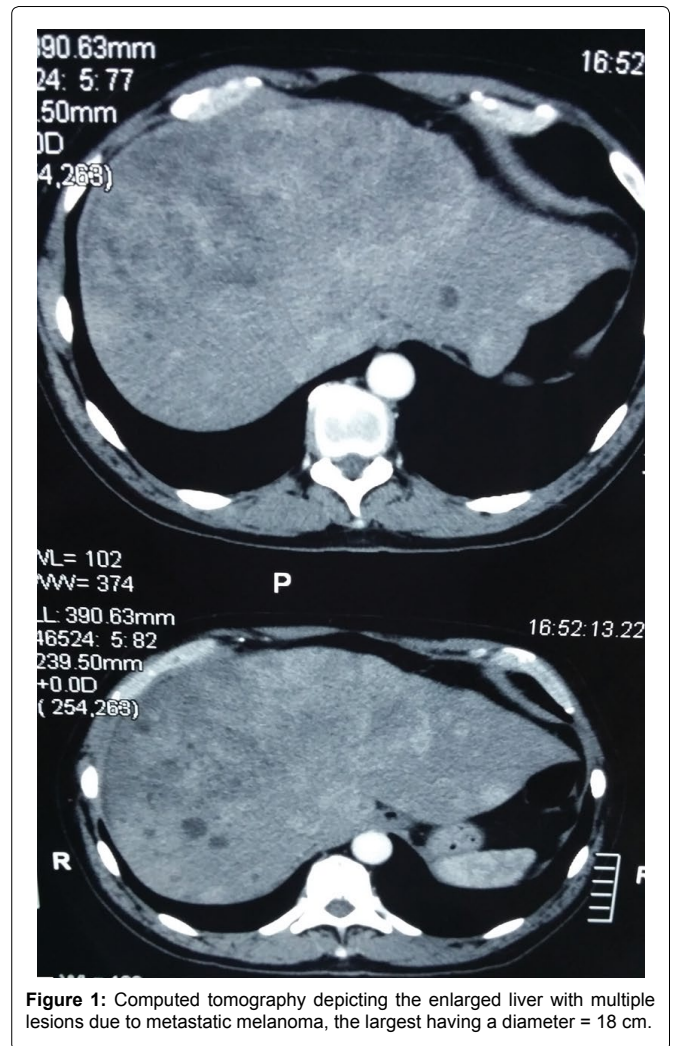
Computed tomography depicting the enlarged liver with multiple lesions due to metastatic melanoma, the largest having a diameter = 18 cm.
